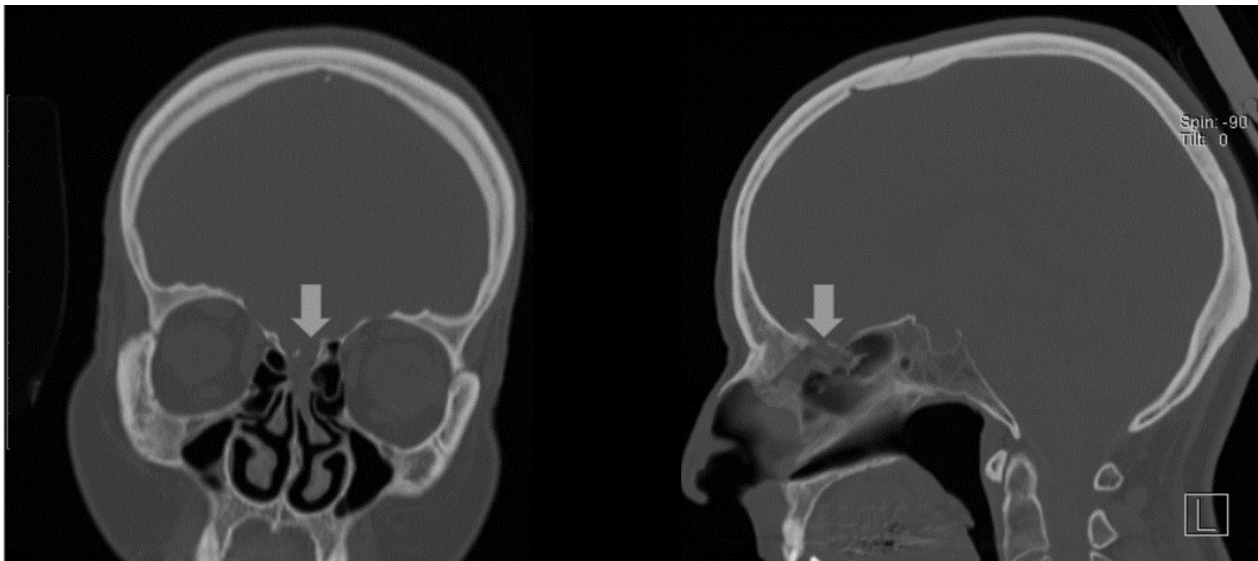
CT scan (bone window) showing mucosal thickening in the left cribriform plate in conjunction with the olfactory fila presenting defect in the adjacent skull base
